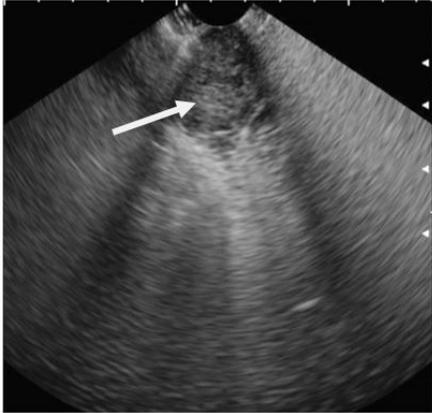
Ultrasound showing hypo echoic lesion on the dorsal aspect of tongue on the left side
